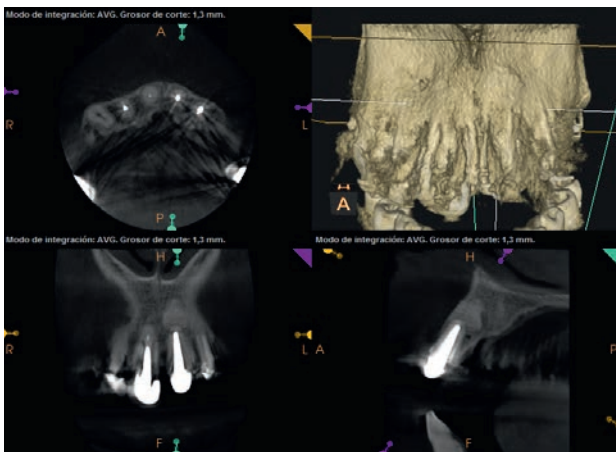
18 months control CBCT image of upper left central incisor after periapical microsurgery with guided bone regeneration, which shows healing of the previous periapical radiolucent lesion.
